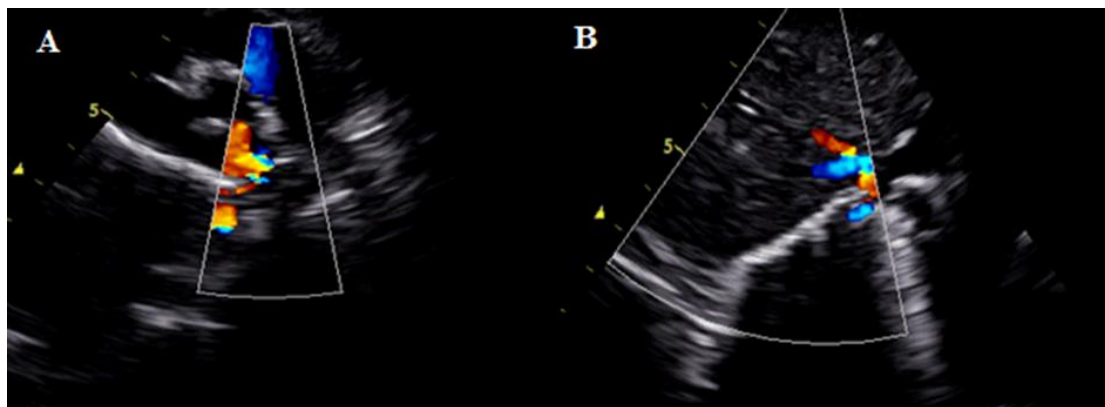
A: Transthoracic echocardiography parasternal short axis view showing a draining acceleration of the flow at the right pulmonary artery. B: Transthoracic echocardiography showing the scimitar vein into the inferior vena cava on a 2-dimensional image
